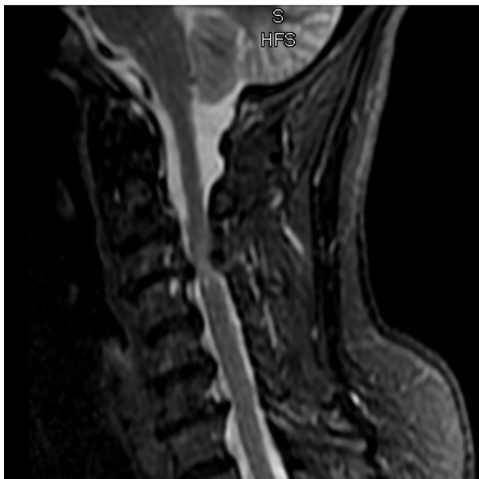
Preoperative MRI demonstrating cervical cord compression with signal change in the cord.
